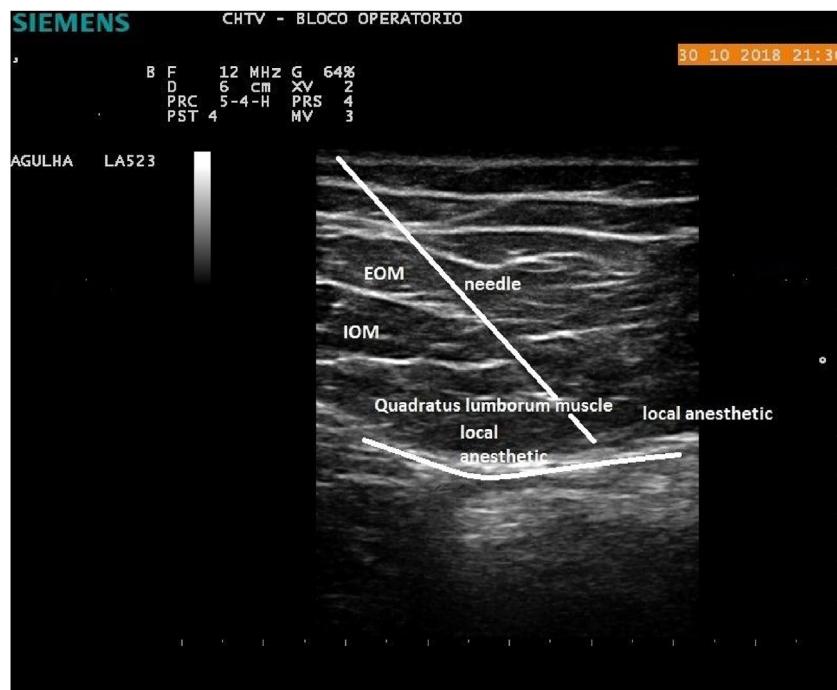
Quadratus lumborum block Type 1. The patient is kept in dorsal decubitus (right side was lifted by a small pillow). The bilateral US-guided QLB1 is performed using a 21G 85 mm needle (Echoplex, Vygon®, Ecouen, France), which is directed in-plane to a high-frequency ultrasound beam (probe: Acuson® P300 ultrasound system, Siemens AG®, Muenchen, Germany) was used. We visualize the LA spread in a medial direction in the anterior surface of Quadratus Lumborum (QL) posteriorly to the anterior layer of TLF. IOM, Internal Oblique Muscle; EOM, External Oblique Muscle (patient granted authorization for the publication of this image).
